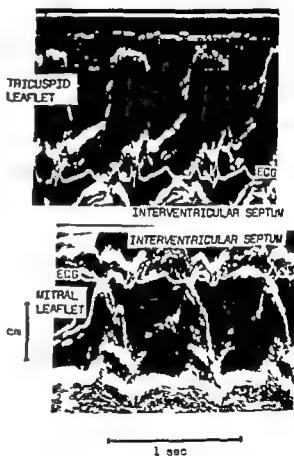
C S 6 years of age Ebsteins anomaly of the tricuspid valve UCG of anterior tricuspid leaflet and the interventricular septum (upper part) and the interventricular septum and the anterior mitral leaflet (lower part) Both recordings were obtained with the transducer in the 4th left intercostal space the lower part a little more to the left and both with the ultrasonic beam in antero posterior direction Note the abnormally anterior position of the echo from the anterior tricuspid leaflet during the entire diastole
